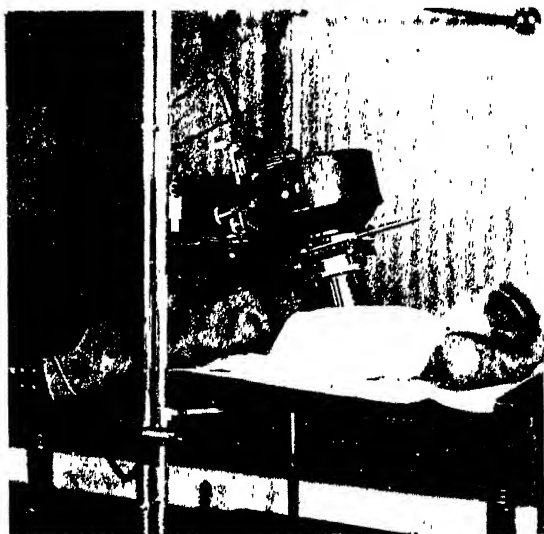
POSITION FOR RADIOGRAPHY OF KIDNEY.
